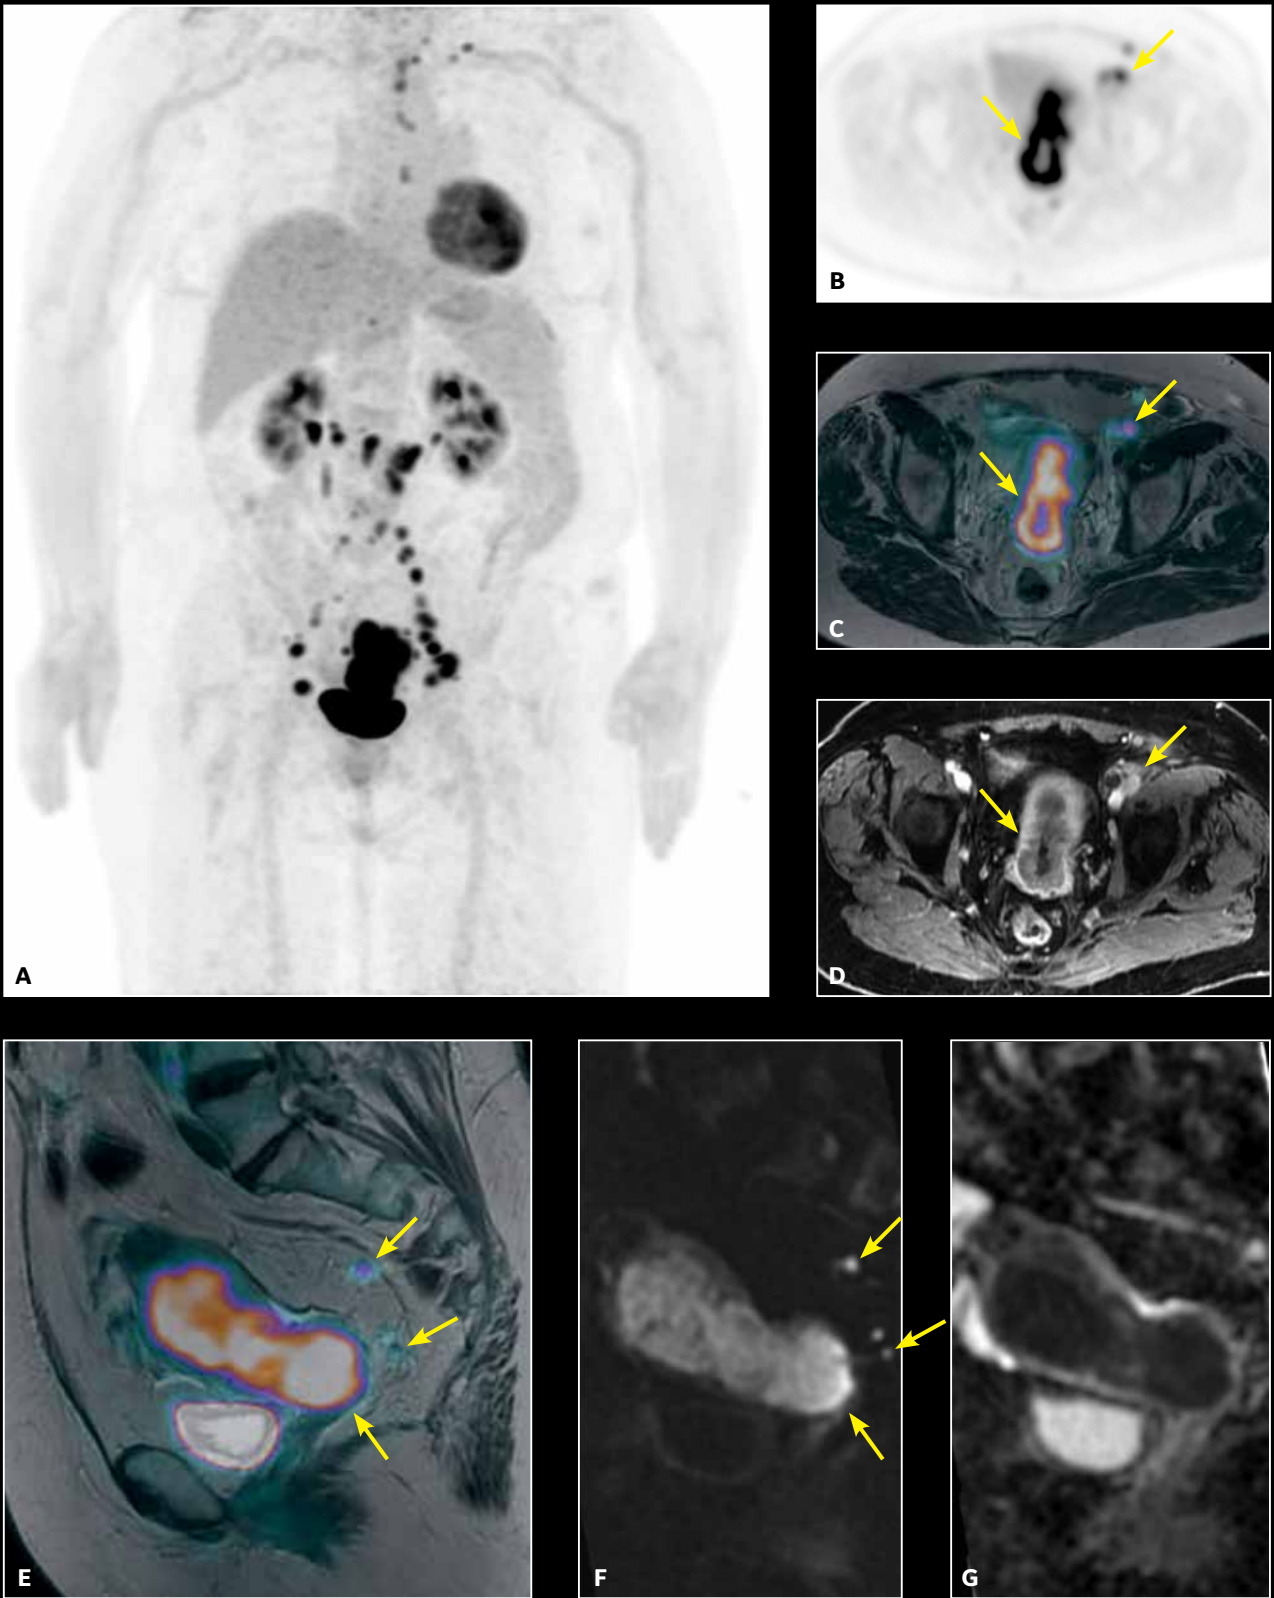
Pelvic MR exam on a patient with endometrial adenocarcinoma. (A) Whole-body PET, 4 bed positions at 3 min/bed; (B) pelvic PET acquired in 16 min; (C) fused PET with Axial T2w PROPELLER; (D) Axial T1w LAVA post-contrast; (E) fused PET with Sagittal T2w PROPELLER; (F) Sagittal FOCUS DWI, b1000; (G) ADC map.
